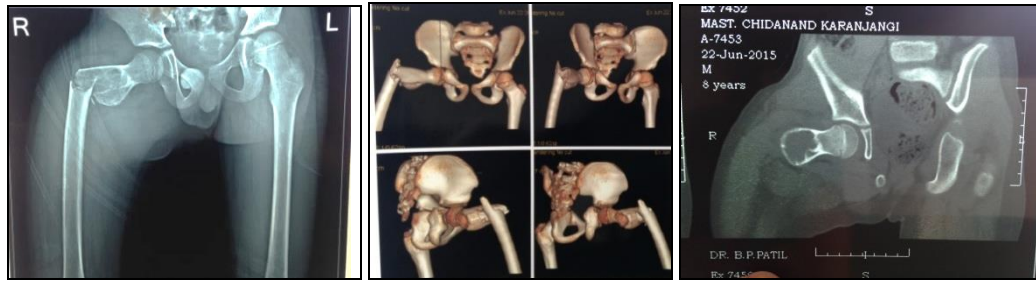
Pre operative radiographs
